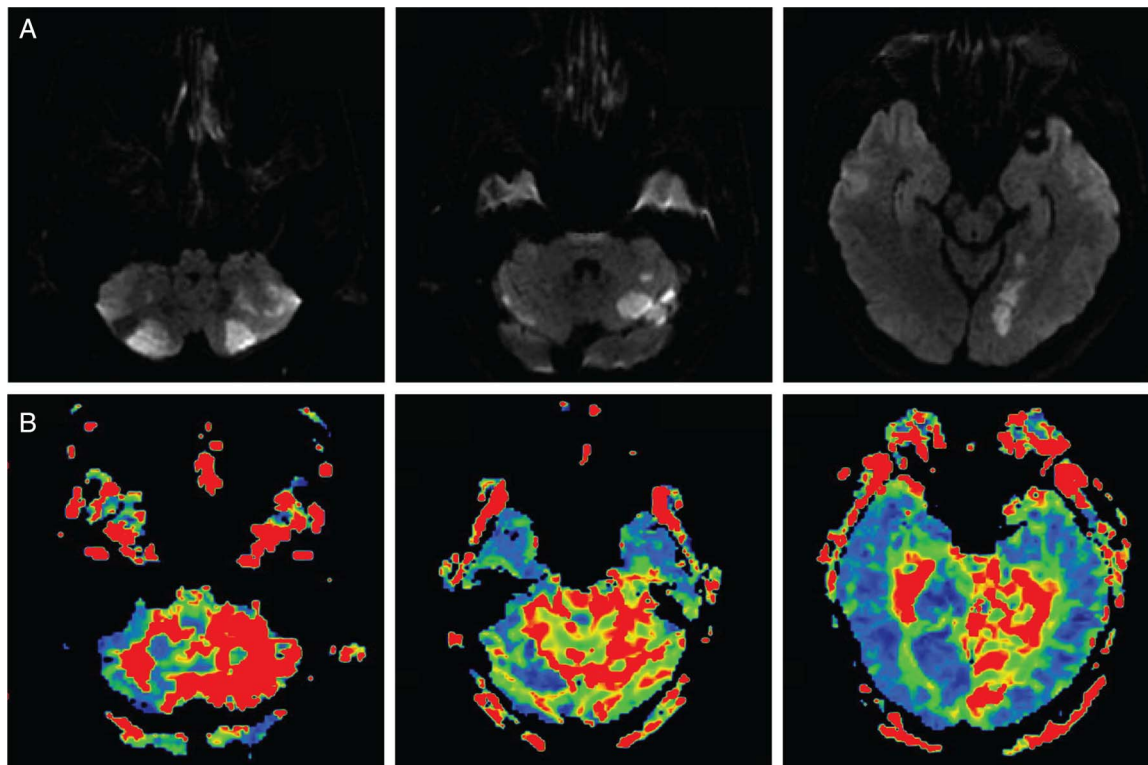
(A) Initial brain diffusion-weighted MRI shows diffusion restriction in both the posterior inferior cerebellar artery and left posterior cerebral artery territory. (B) Perfusion MRI shows delay of mean transit time in the bilateral cerebellum, brainstem, and left occipital lobe.
